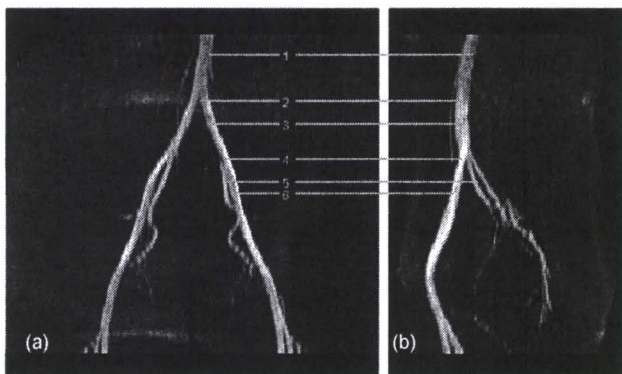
MRI images of blood vessels in a healthy volunteer. Front view (a) and side view (b). Indicated are: 1) Aorta, 2) Aorta bifurcation, 3) Common iliac, 4) Iliac bifurcation, 5) Internal iliac and 6) External iliac
